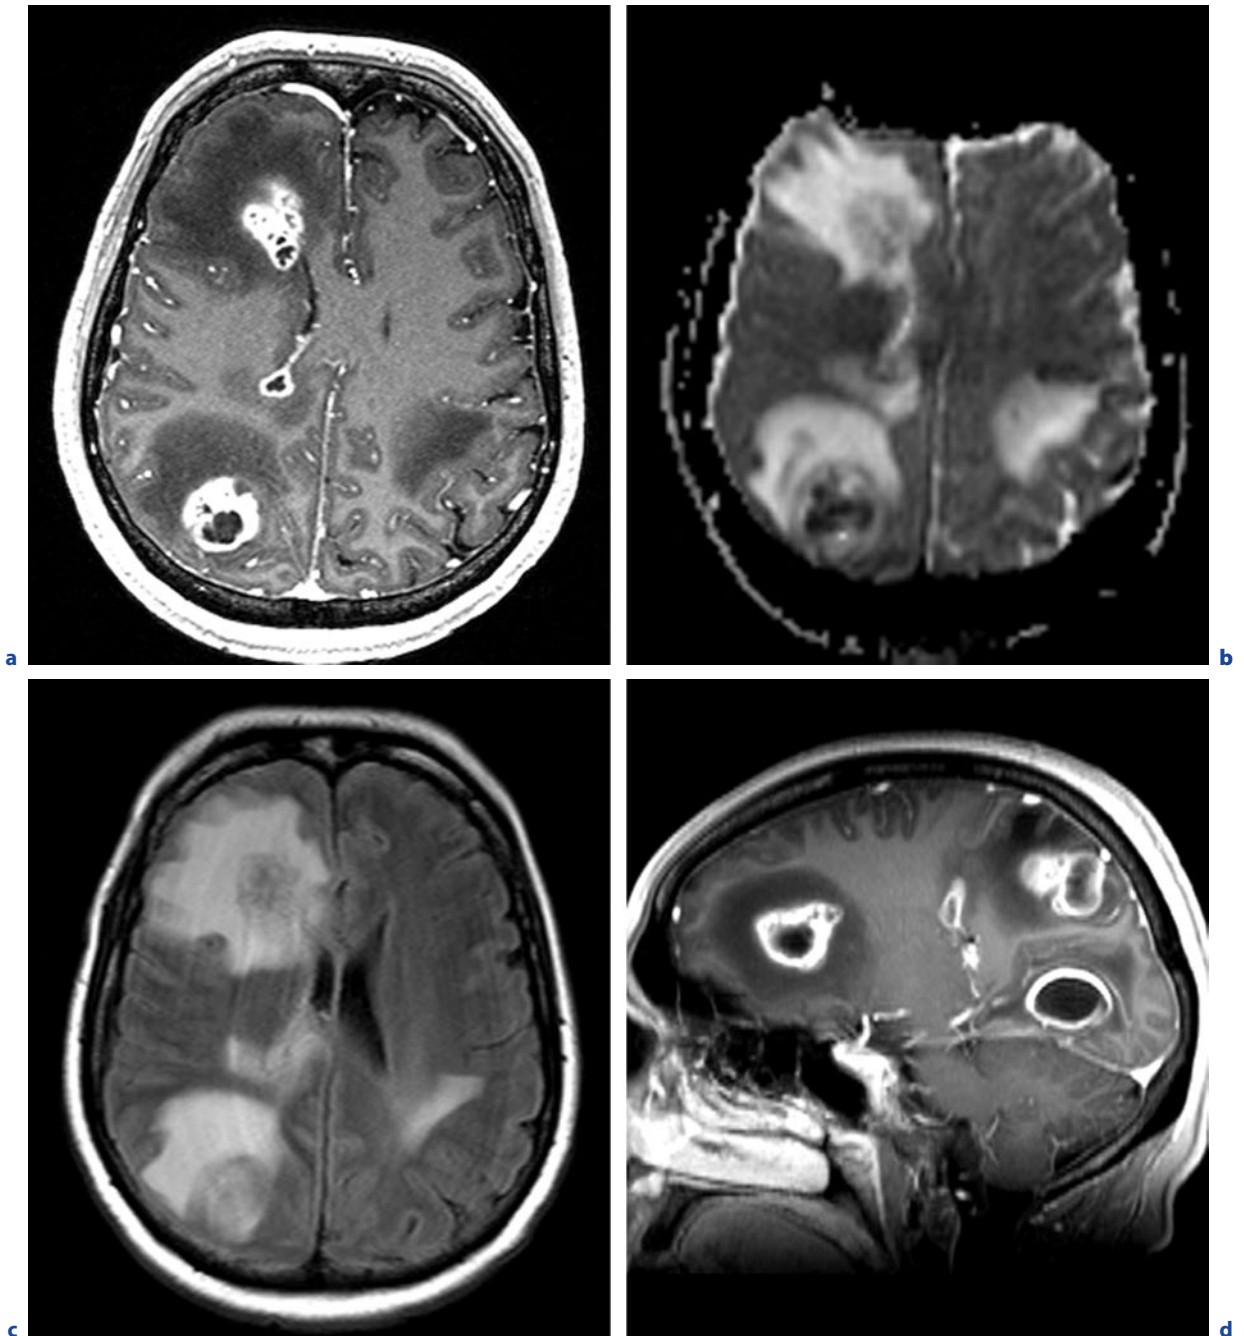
Multiple brain abscesses caused by *Fusobacterium nucleatum* in a 51-year-old immunocompromised woman with seizures. a Axial T1-weighted MR image after contrast administration. b Axial ADC map. c Axial FLAIR image. d Sagittal T1-weighted image after contrast administration. T1-weighted MR images after contrast administration (a,d)
